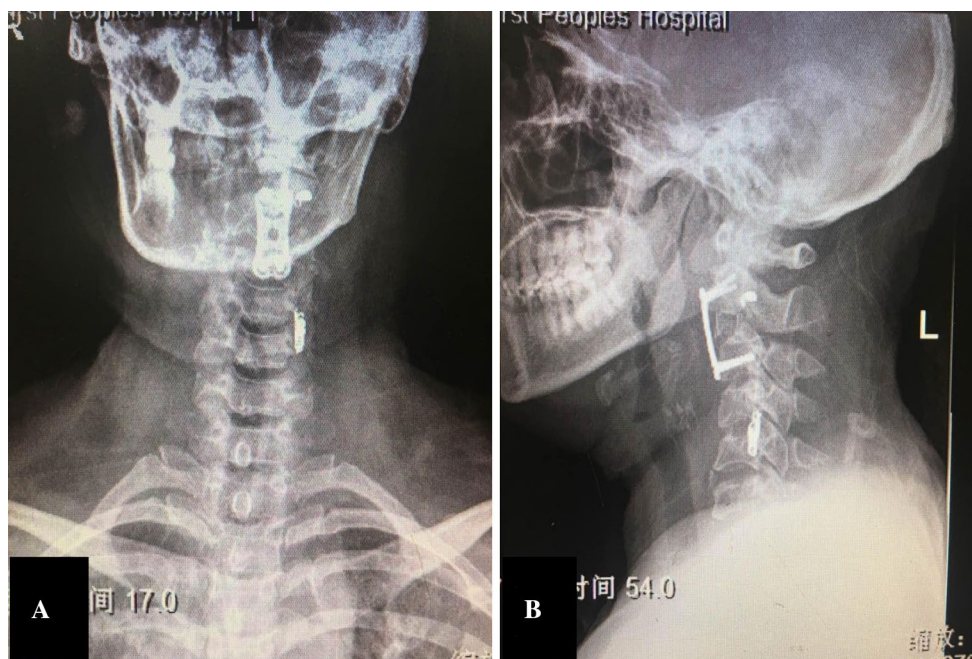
Postoperative cervical radiograph (a, b) showing a C2/3 cage and plate anteriorly and the left vertebral artery embolism via transcatheter unilateral embolization at the C2 and C5 levels
